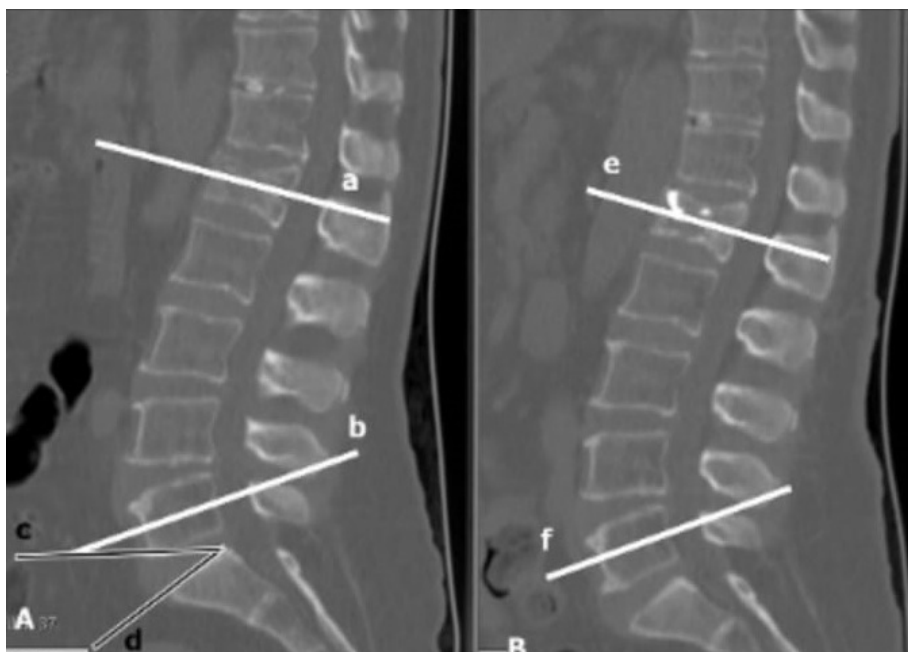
LL angle (between lines a and b) on a sagittal CT image. (A) Preoperative SS angle (between lines c and d), and (B) no significant change in LL angle (between lines e and f) seen postoperatively.
